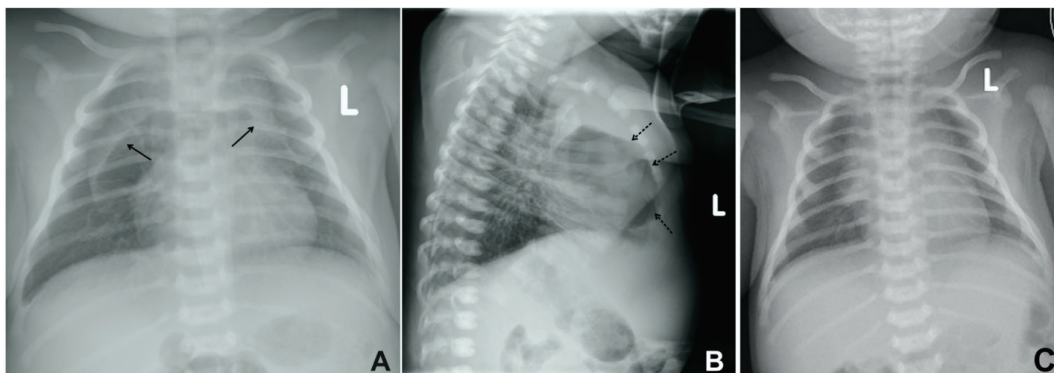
(A) Anteroposterior (AP) chest radiograph demonstrates pneumomediastinum with the thymic lobes (black narrows) are elevated off the heart due to the underneath air collection. (B) Lateral chest radiograph reveals retrosternal air collection (dashed narrows). (C) AP chest radiograph after 3 days shows the thymic lobes at normal position without displacement.
